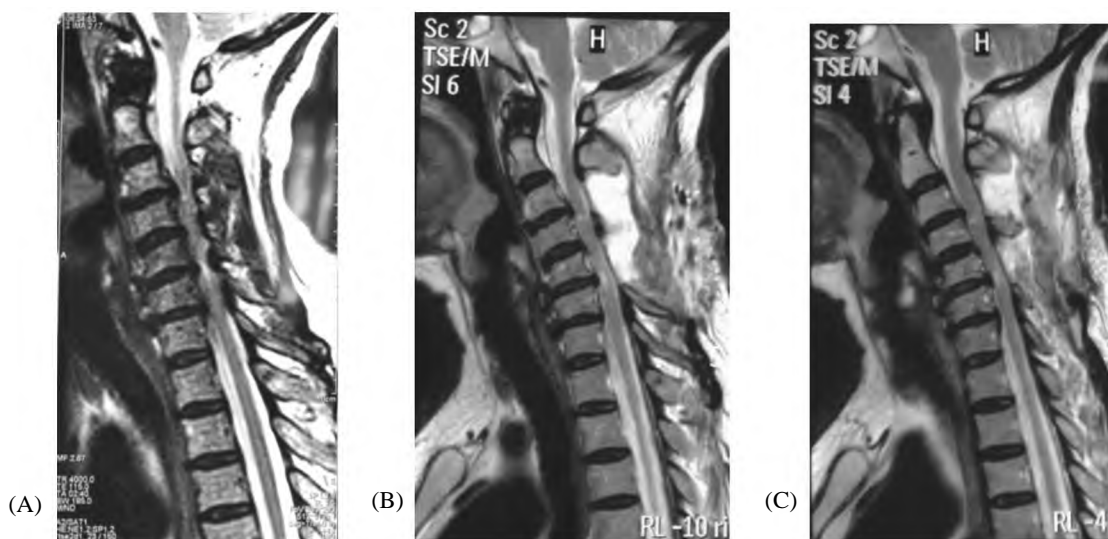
(A) Preoperative MRI cervical region showing cervical canal stenosis with cord Malacia (B,C) Follow-up MRI showing adequate decompression by skip laminectomy technique.
